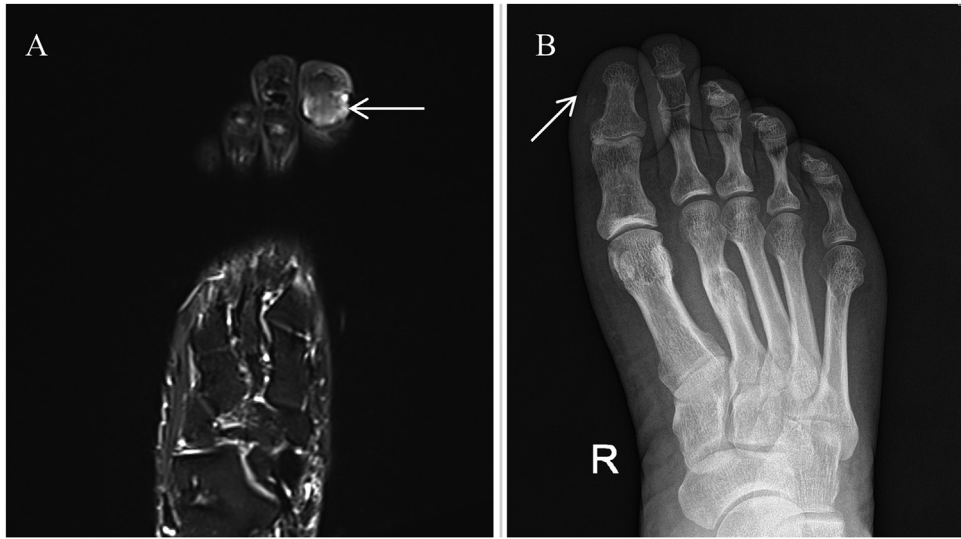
Coronal fat-suppressed T2WI showing a long flaky T2 signal (arrow) at the distal nail bed of the right great toe (A). The X-rays showing a slightly rough bone density in the distal phalanx of the right great toe, along with swollen soft tissues around the distal phalanx and punctate calcification (arrow) (B).
